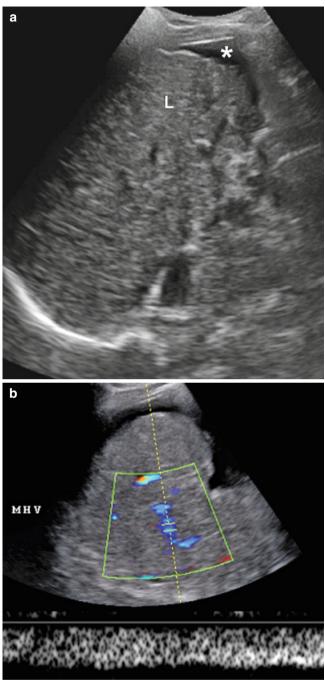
Monophasic hepatic vein waveform with cirrhosis. (a) Sonogram of right upper abdomen demonstrating lobular contour of liver (*L*) and ascites (*). (b) Color and spectral Doppler of middle hepatic vein in same patient showing monophasic flow away from the liver toward the heart
